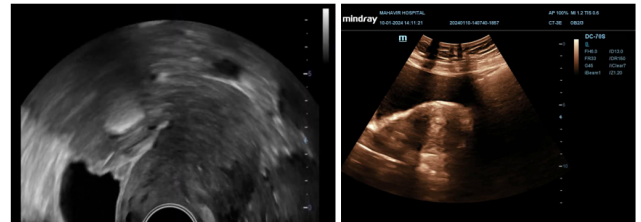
Transvaginal sonography performed on January 11, 2024
